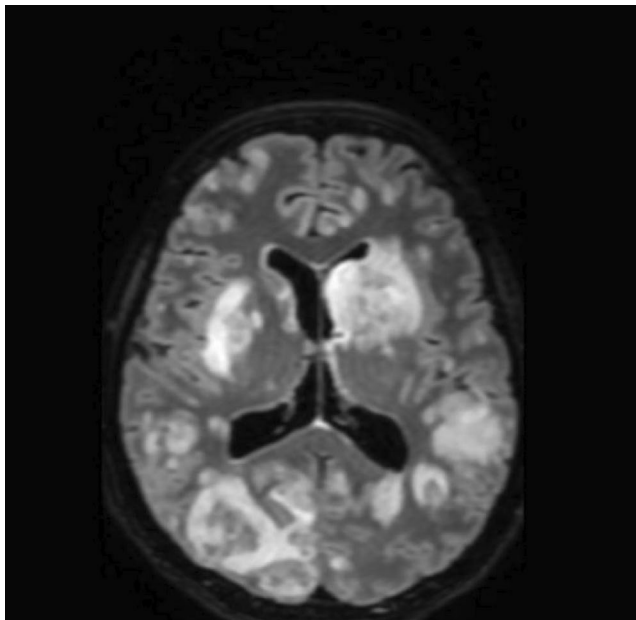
CASE 1 Multiple FLAIR-hyperintense lesions, with the concentric target sign seen in the deep parenchymal lesions.
